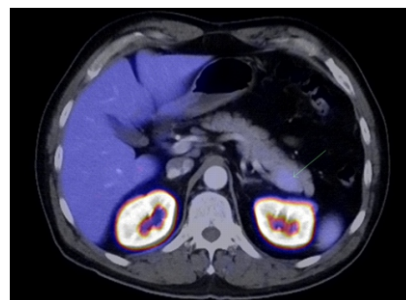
Axial fused ^{18}F -PSMA PET/CT image showing focal mild PSMA uptake in the tail of the pancreas, with associated mild contour bulging posteriorly on CT.
